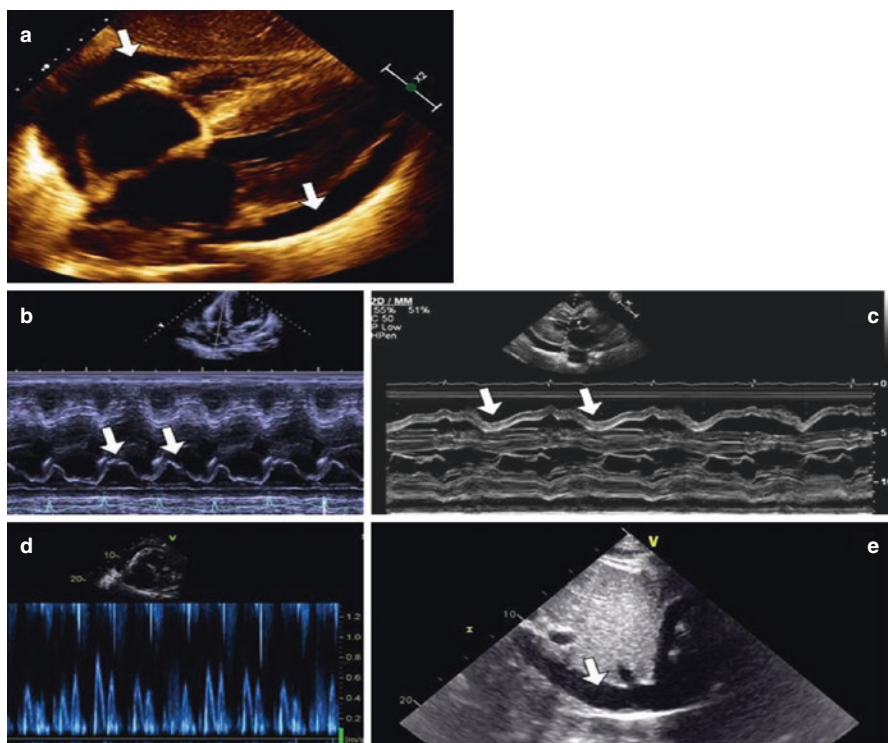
Assessment of pericardial effusion. While circumferential pericardial effusion is commonly easy to recognize by echocardiography (panel a, arrows), the assessment of tamponade physiology requires comprehensive echocardiography. M-mode echocardiography allows precise timing of events such as presence and duration of right atrial collapse in apical four-chamber view (panel b, arrows) and diastolic right ventricular outflow tract collapse timed against mitral valve opening and closing in modified parasternal long-axis view (panel c, arrows). Confirmatory signs include flow variation across the mitral valve (panel d) and inferior vena cava engorgement (panel e, arrow)
